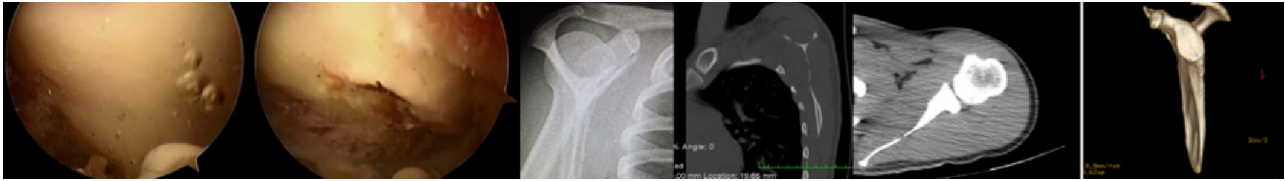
Intraoperative, radiographic, and tomography images, post bone tumor resection.
